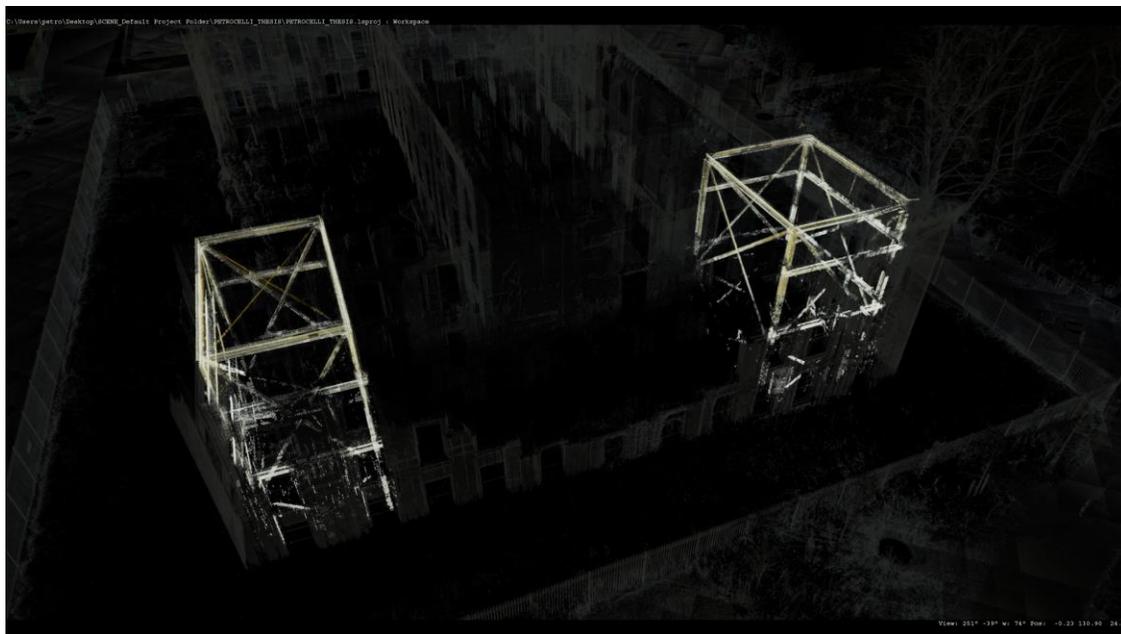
Entry & Embrace; Smallpox Hospital Xray
